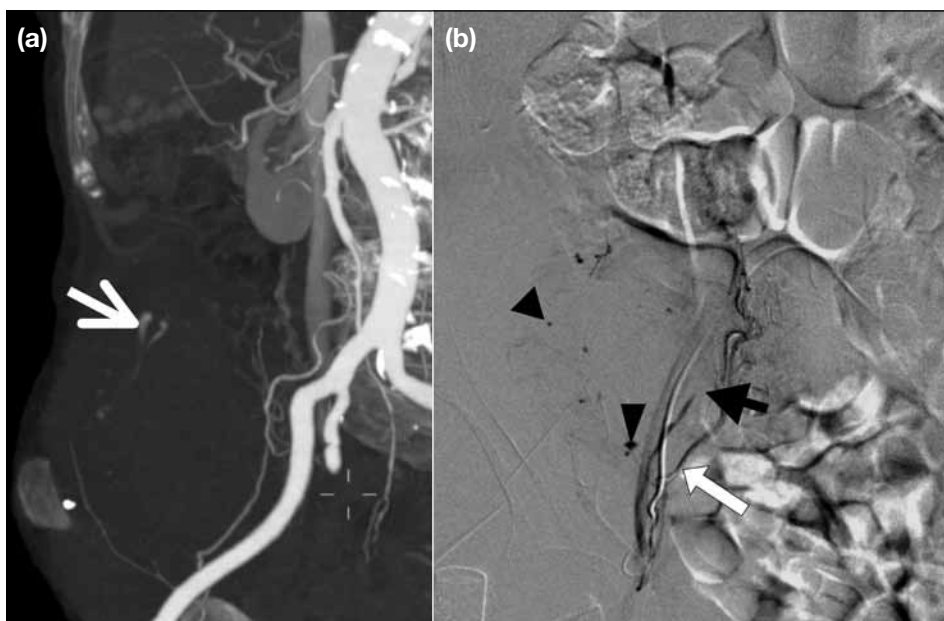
(a) Reformatted maximum intensity projection image of contrast-enhanced computed tomography showing large right rectus sheath haematoma with active contrast extravasation (arrow). (b) Digital subtraction angiography showing cannulation of the right external iliac artery with a 5-Fr catheter (black arrow) and placement of the microcatheter at the right inferior epigastric artery (white arrow), with active contrast extravasation (arrowheads).
